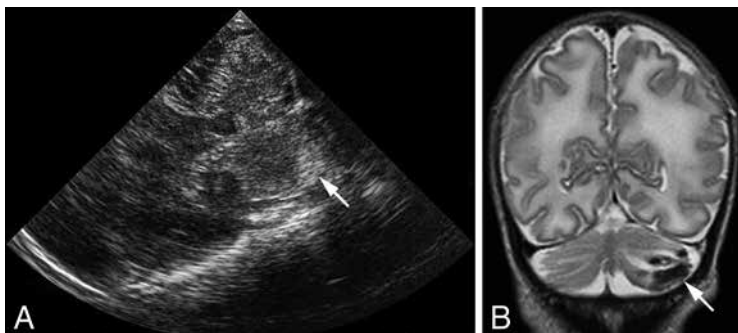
Term neonate (gestational age 40 weeks) born after emergency caesarean section performed for fetal distress, with good Apgar scores. On the 2nd day of life CUS was performed because he was hypertonic and irritable. Conventional CUS using the AF revealed no abnormalities. (A) Coronal CUS using the right MF as acoustic window demonstrates an echogenic lesion in the left hemisphere, suspect for hemorrhage (arrow). (B) Coronal T2-weighted MRI in the same neonate confirms the hemorrhage in the left cerebellar hemisphere (arrow).
